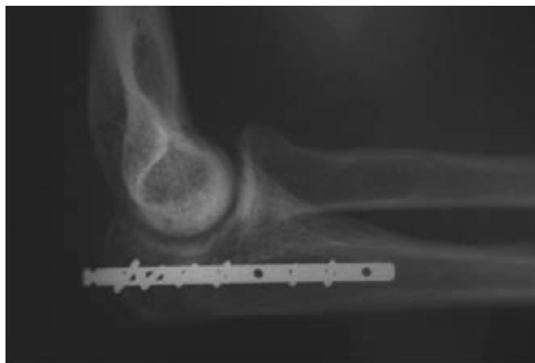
Lateral radiograph after osteosynthesis shows the intramedullary position of the implant, as well as the compression screw (left on lateral view).
